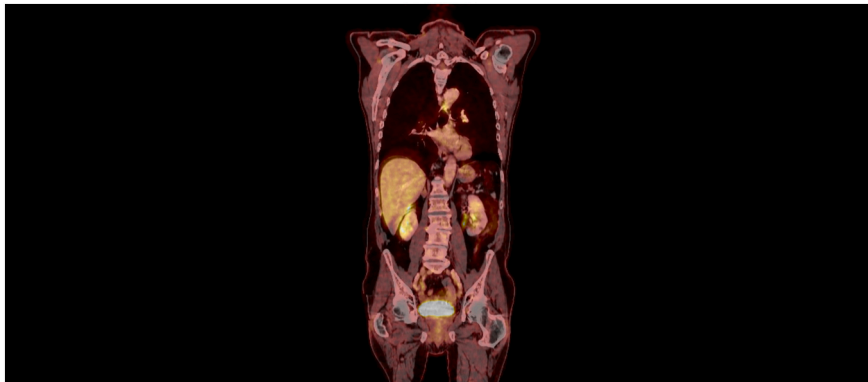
PET/CT - check-up examination after neoadjuvant therapy; partial response to cancer treatment.
